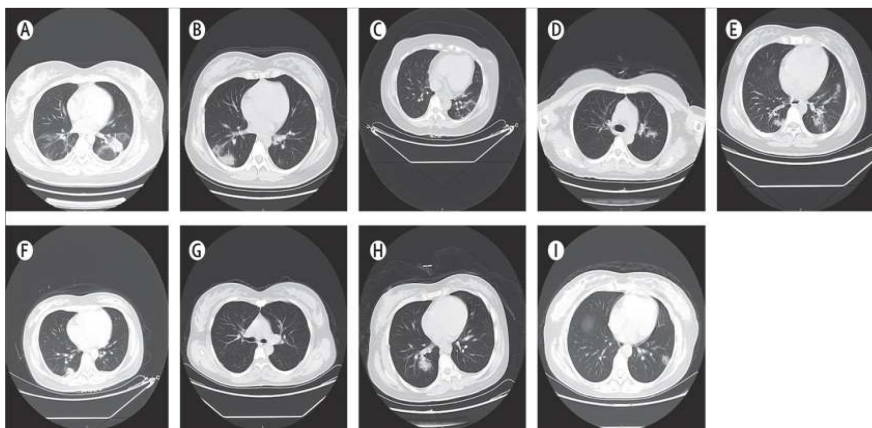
Ground glass opacities in CT scans of nine patients (Huijun Chen ph.D, Juanjuangou MS, 2020, LANCET)
